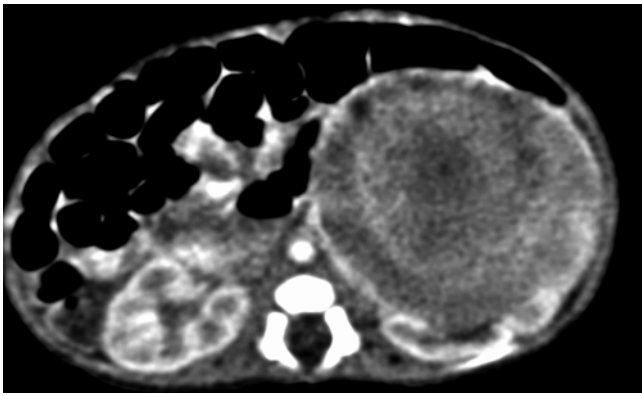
Mesoblastic nephroma. A large left renal tumor is demonstrated on CT scan of kidneys in this 10-month-old infant. Nephrectomy confirmed mesoblastic nephroma
